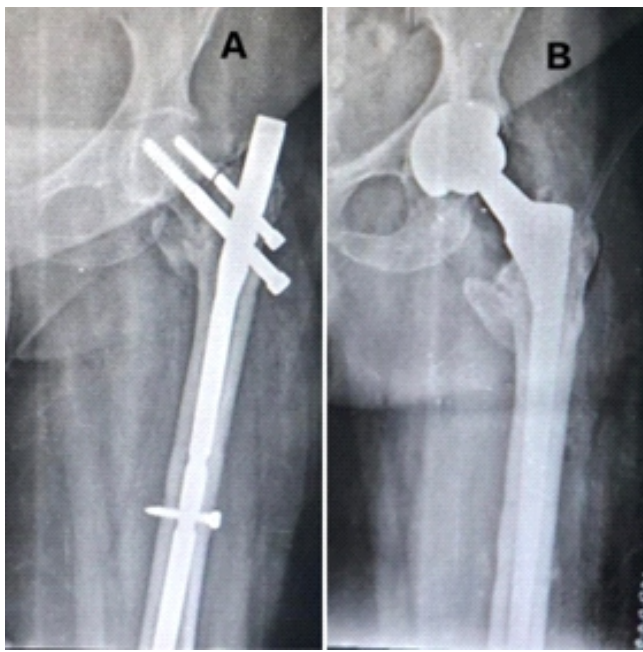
(a) 5 months post-operative anterior-posterior (A-P) view X-ray showing screw-breakage in pertrochanteric femur fracture of the left side fixed with short proximal femoral nail. (b) Post-operative A-P view X-ray showing total hip replacement done after implant removal.
